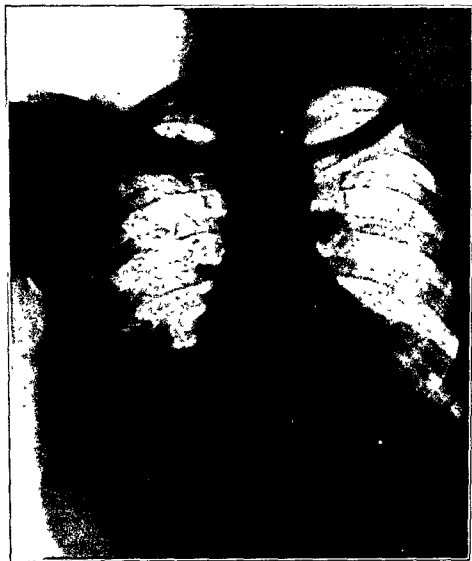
A month has elapsed since the taking of x-ray in Fig. 55. Note the disappearance of the huge cavity that has occupied almost all of the right upper lobe. There is a dense shadow in the first interspace, the remains of the collapsed cavity.
